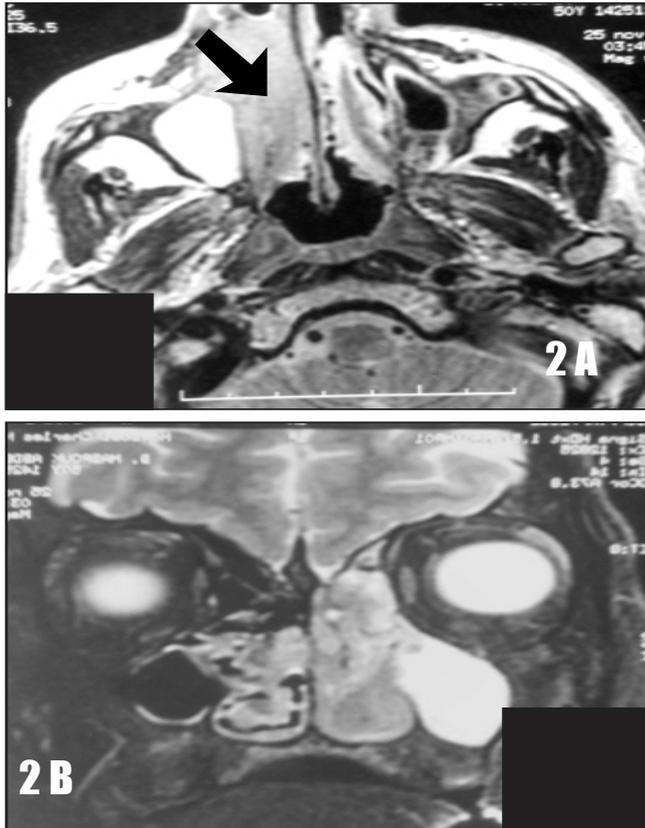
and figure 2B: MRI imaging: T1-gadolinium axial section and T2 coronal section showing a nasal right process infiltrating the ethmoid with retention image in the ipsilateral maxillary sinus.
